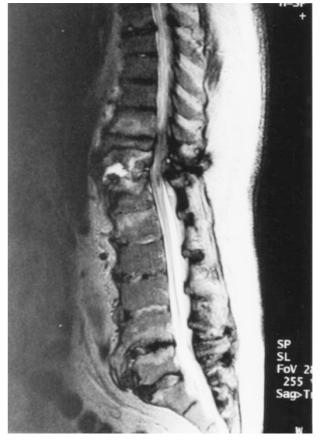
MRI of Thoracolumbar spine, sagittal T2-weighted image. Pseudoarthrosis at T10-11 level with loss of vertebral height at both levels and associated signal change in the disc and posterior elements. There is moderate narrowing of the canal at this level. Gross degenerative changes are seen at L4-5
